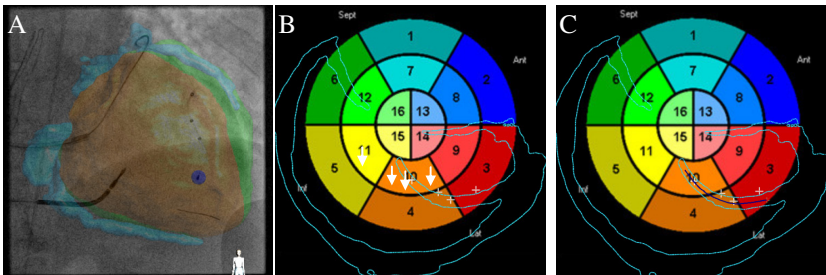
(A) Overlay of the LV and CS onto an X-ray image. The blue sphere is the position of the lead electrode. (B) 2D unfolding navigation screenshot. The light blue contour is the CS tree unfolded in the 2D bull's-eye plot. The white crosses are the positions of the pacing leads. (C) Screenshot with the manual annotation of the centerline of the CS sub-branch (the dark blue line).
